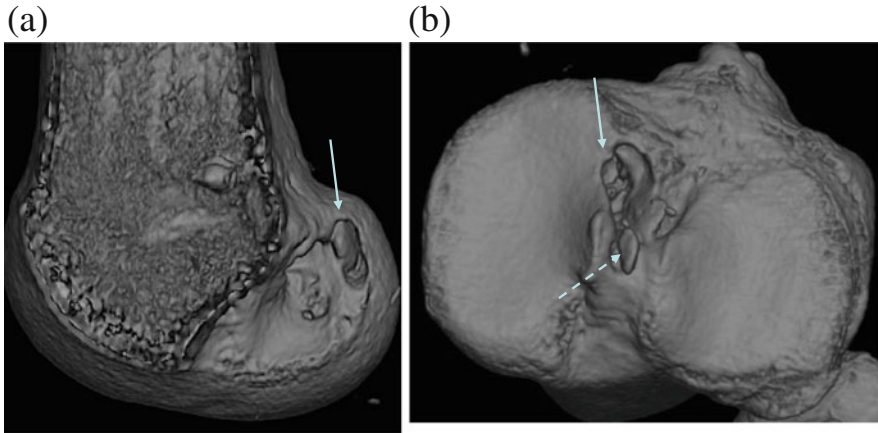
3-D CT pictures showing femoral and tibial tunnel apertures after the revision ACLR for Case 1. (a) Note the new anatomic rectangular femoral tunnel aperture (*solid arrow*) with the bone plug inside (*solid arrow*). (b) Note the new rectangular tibial tunnel aperture just anterior to the previous one (*solid arrow*). Note the bone graft behind the tunnel to fill out the primary tunnel (*dotted arrow*)
